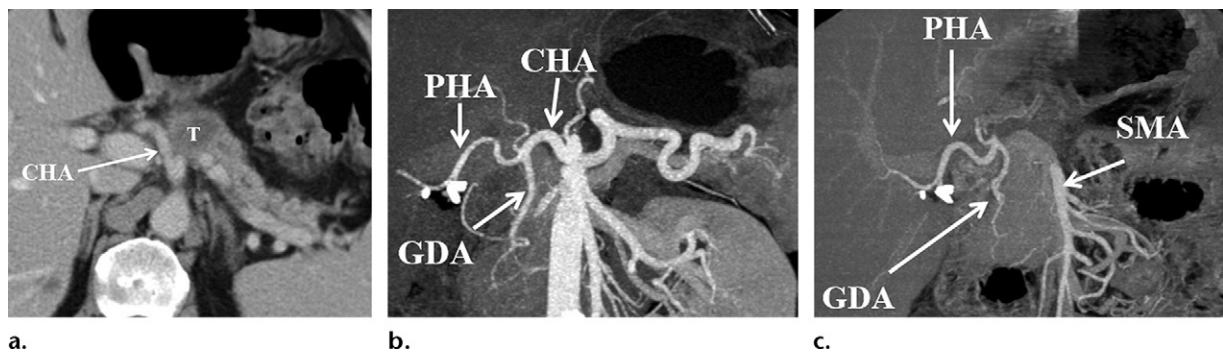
PDAC in the pancreatic body in a 59-year-old man. (a) Axial CT image shows a pancreatic body tumor (*T*) abutting the common hepatic artery (*CHA*). (b) Preoperative three-dimensional maximum intensity projection CT image shows a patent gastroduodenal artery (*GDA*). *CHA* = common hepatic artery, *PHA* = proper hepatic artery. (c) Postoperative three-dimensional maximum intensity projection CT image shows a successful common hepatic artery resection without the need for reconstruction, because the blood flow to the liver is maintained owing to the collateral pathway between the SMA and the proper hepatic artery (*PHA*) through the gastroduodenal artery (*GDA*).
